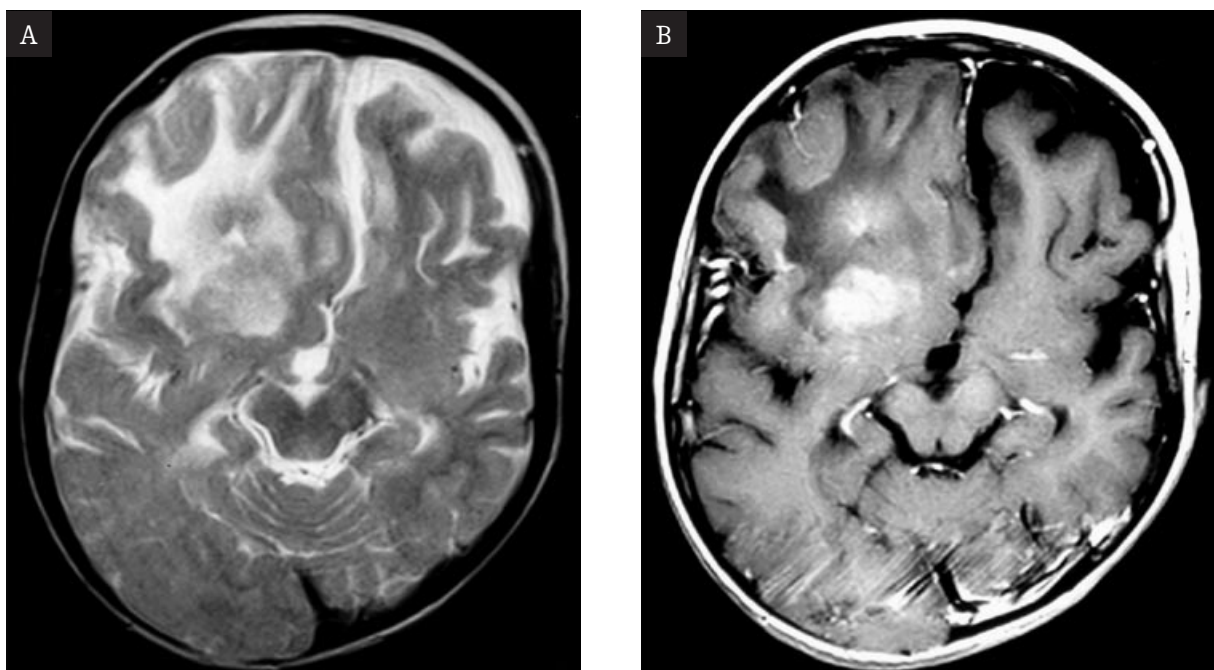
Frontal metastasis of the right cerebral hemisphere in a child with previous resection of the PNET in left frontal lobe. Axial T2-weighted (A) and post-contrast T1-weighted images (B) show mass with surrounding edema in the deep white matter of the frontal lobe.
